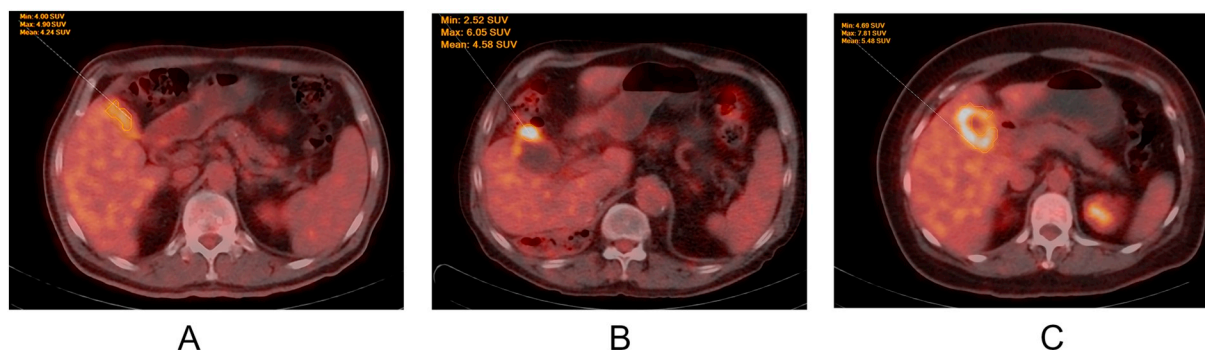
Axial fused PET and CT images with ^{18}F -FDG at the level of the upper abdomen showing incidental gallbladder uptake and adaptive threshold SUV measurements with the three patterns encountered: diffuse increased uptake in the entire gallbladder (pattern 1, A), focal uptake in the gallbladder wall (pattern 2, B) and diffuse increased uptake in the gallbladder wall only (pattern 3, C).
